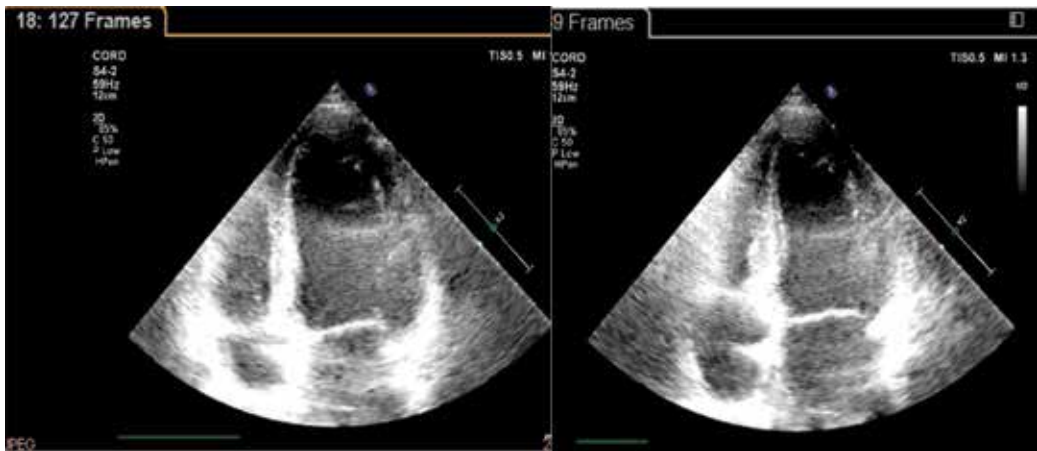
Echocardiography apical view before and after ablation of the cavo-tricuspid isthmus in a patient with dilated cardiomyopathy due to 2:1 typical atrial flutter.
